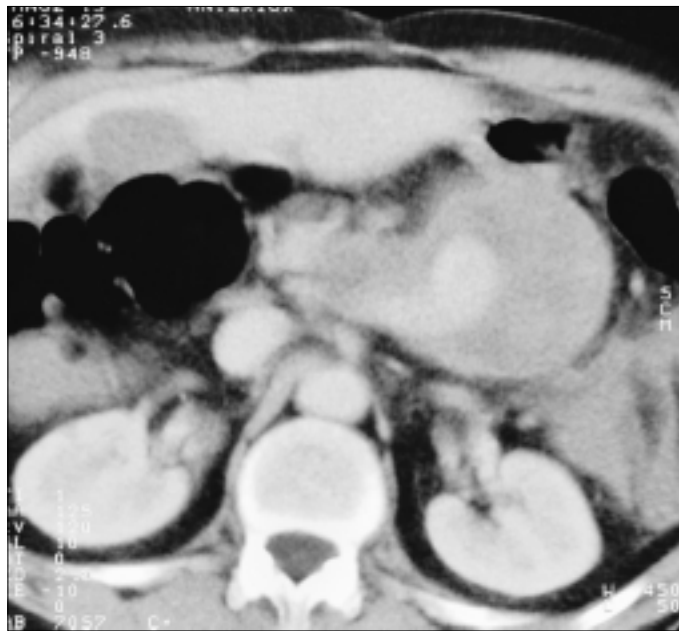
Computed tomography scan showing the splenic artery aneurysm.
